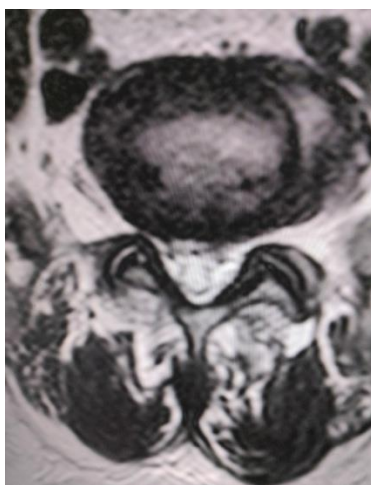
Axial T2 weighted Image of MRI Sequence shows Ligamentum Flavum Hypertrophy
